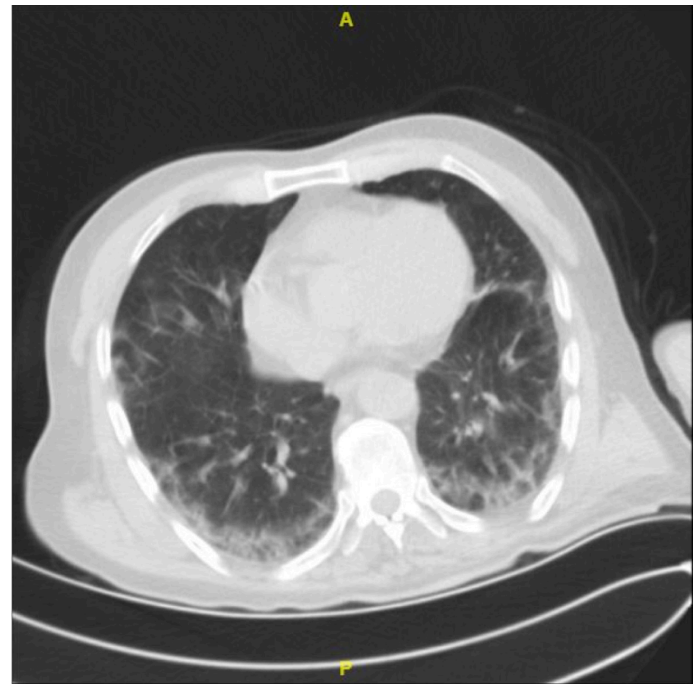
CT thorax scan of the patient while emergency admission
